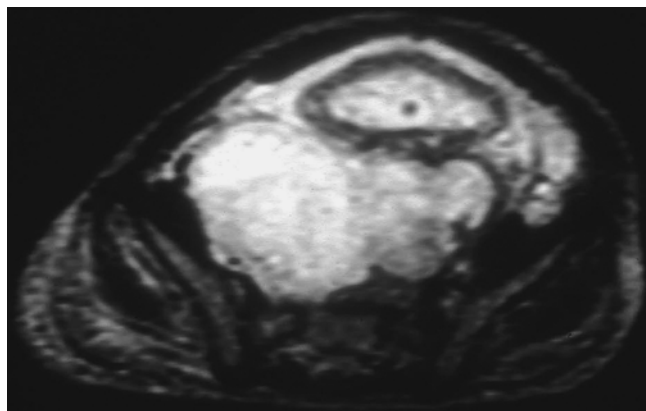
CT scan demonstrating a pelvic mass associated with a vaginal germ cell tumor
